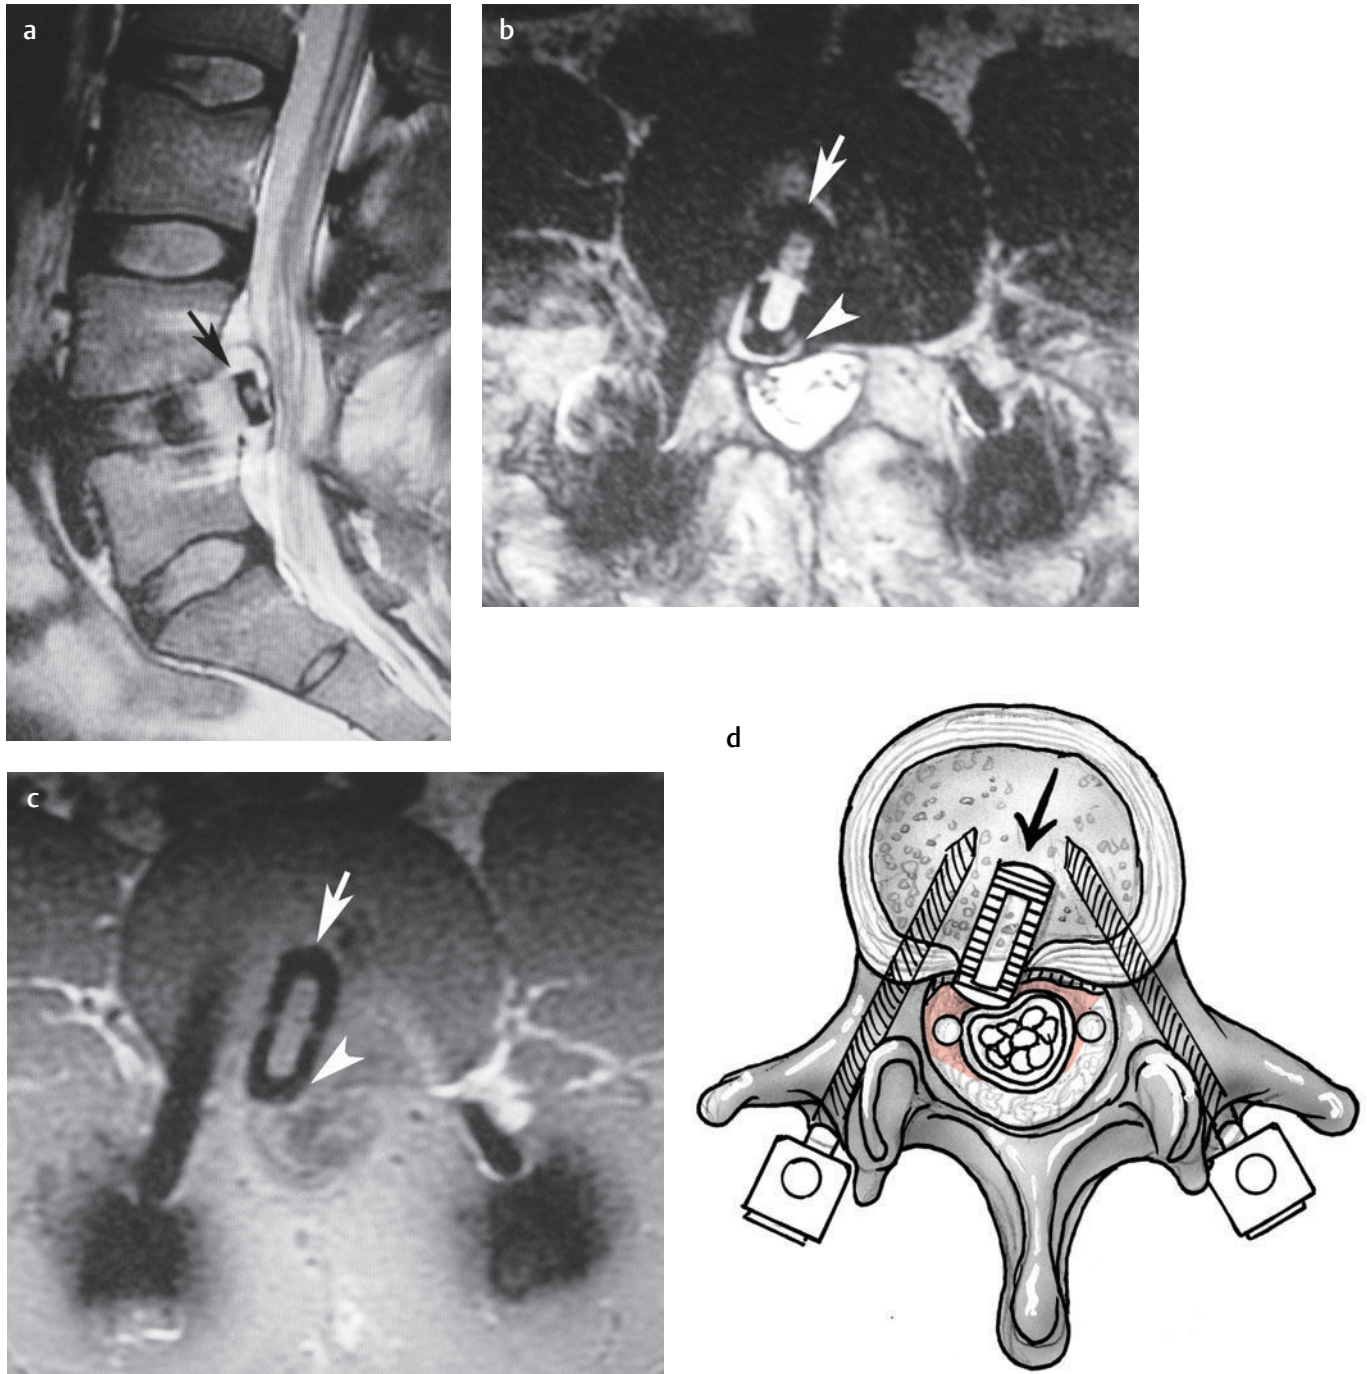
Retropulsed interbody device. (a) A sagittal T2-weighted image shows retropulsion of an L4-L5 transforaminal interbody device (*arrow*) into the spinal canal.[†] An axial (b) T2-weighted image,[†] (c) T1-weighted image,[†] and (d) artist's sketch show that the interbody device (*arrow* on each) is retropulsed beyond the margin of the posterior vertebral body (*arrowhead* on b and c) and is producing right lateral recess stenosis.
